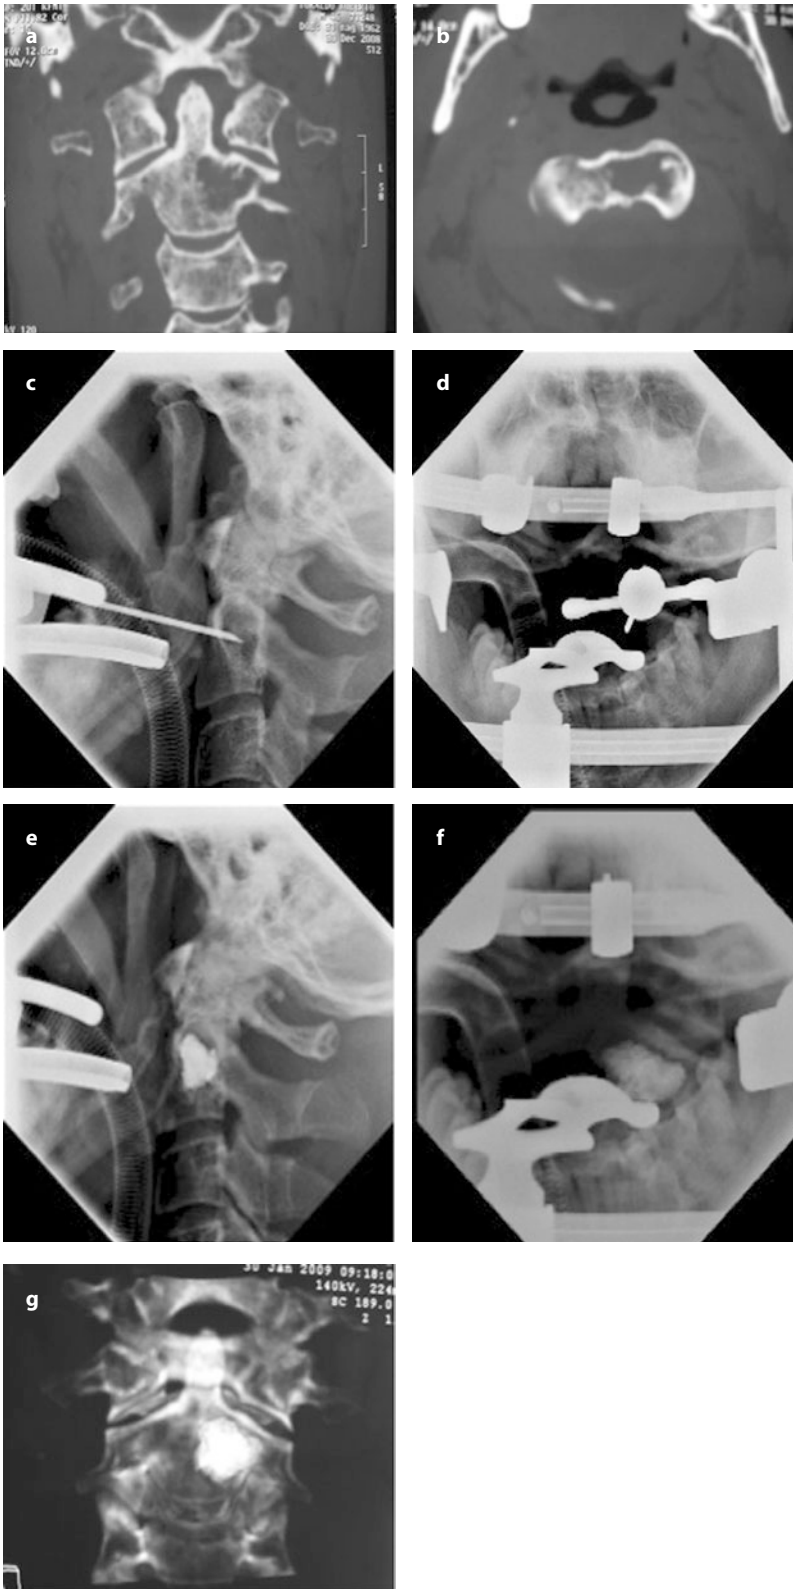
C2 vertebroplasty. Multidetector-row computed tomography (MDCT) coronal and axial MP reconstruction at the cervical level show a multiple myeloma lesion at C2 (a and b). The patient is placed in the supine position under general anesthesia. The mouth remains open by the use of distractors (c and d). Left lateral and anteroposterior views under fluoroscopic control after PMMA injection show good distribution of cement into the lesion without leakage (e and f). Three-dimensional volume-rendered MDCT shows good distribution of the PMMA (g)
